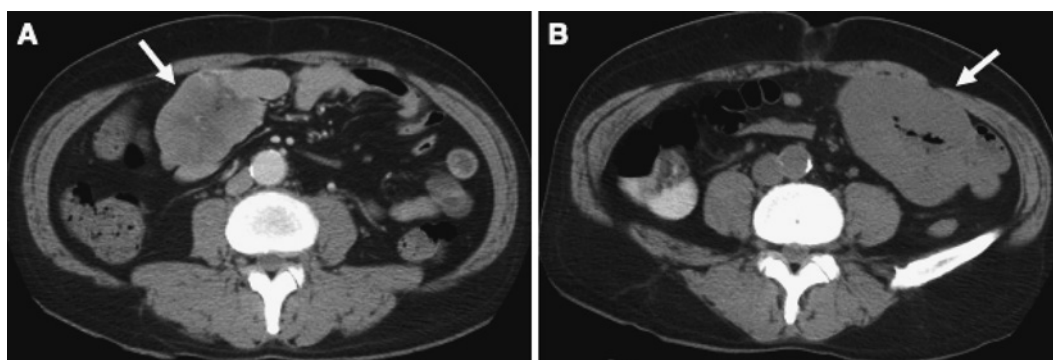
Abdominal computed tomography scan showing a small-intestinal tumor (arrow) (A). The tumor continued to grow while the patient experienced abdominal pain (arrow) (B).
